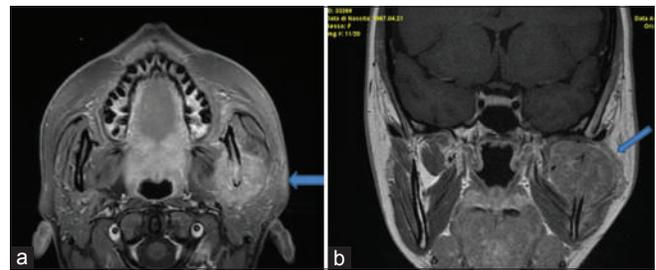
(a and b) Magnetic resonance imaging (MRI) of the patient. MRI compatible with the presence of neoplastic lesion. The expansive lesion is involving the left side of mandibular ramus and condyle
